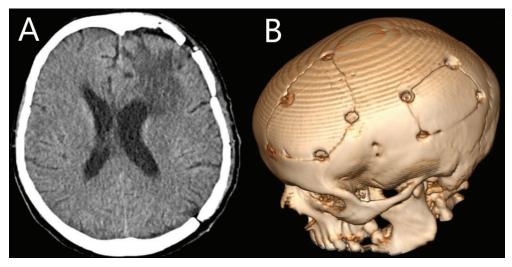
(A and B). CTA of the brain postoperative after meningioma extirpation and epidural hematoma evacuation. Panel A shows hypodense areas anteriorly from persistent perifocal edema at the site of the extirpated tumor. Panel B shows a 3D reconstruction of the skull and craniotomy sites
